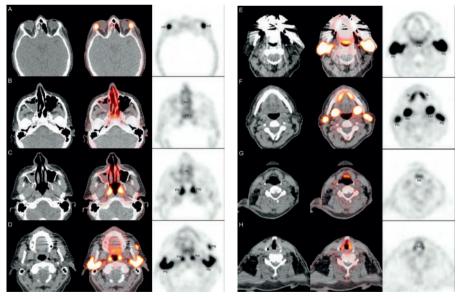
Low dose CT (left), PET/CT (middle) and PET (right) images of the head and neck, showing ⁶⁸Ga-HBED-CC-Glu-NH-CO-NH-Lys(Ahx) uptake in healthy salivary, seromucous, and lacrimal glands in a patient with prostate cancer and no apparent metastatic disease. LG, lacrimal gland; NC, nasal cavity mucosa; NP, nasopharyngeal mucosa; PW, pharyngeal wall; PAL, soft palate; PG, parotid gland; SM, submandibular gland; SL, sublingual gland; SG, supraglottic larynx.
